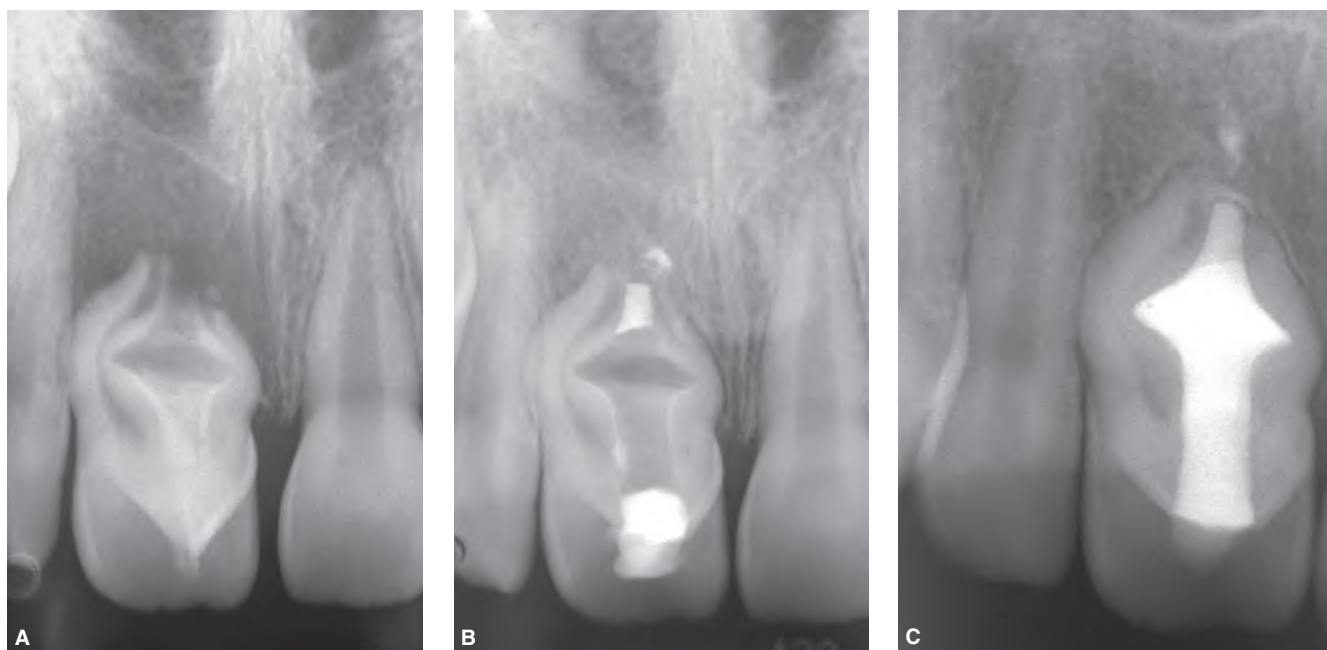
A. Preoperative radiograph of a maxillary right central incisor. Note the periapical radiolucency, the unusual anatomy, and the wide open apex. B. Three millimeters of MTA were placed at the foramen, using the apical barrier technique. C. 2-year recall radiograph showing successful results.
